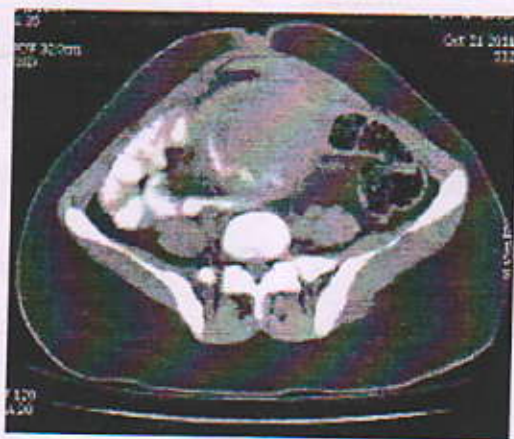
CT showing myometrial necrosis with calcification
